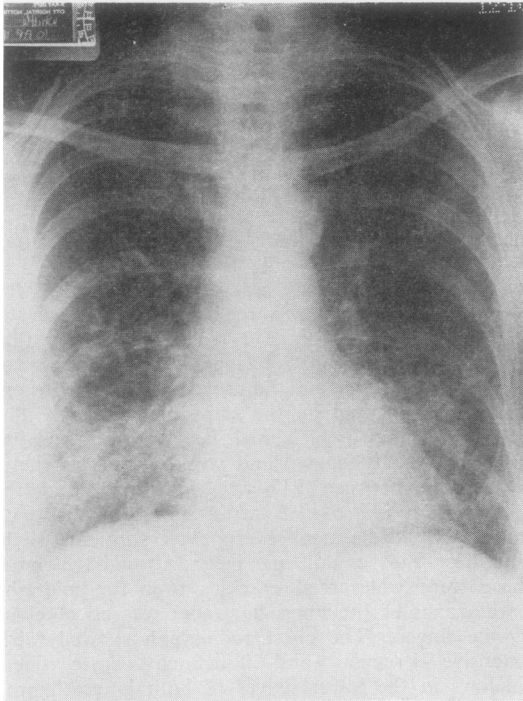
Figure Chest radiograph of patient, showing ill-defined irregular and linear shadows in the lower halves of both lungs.
